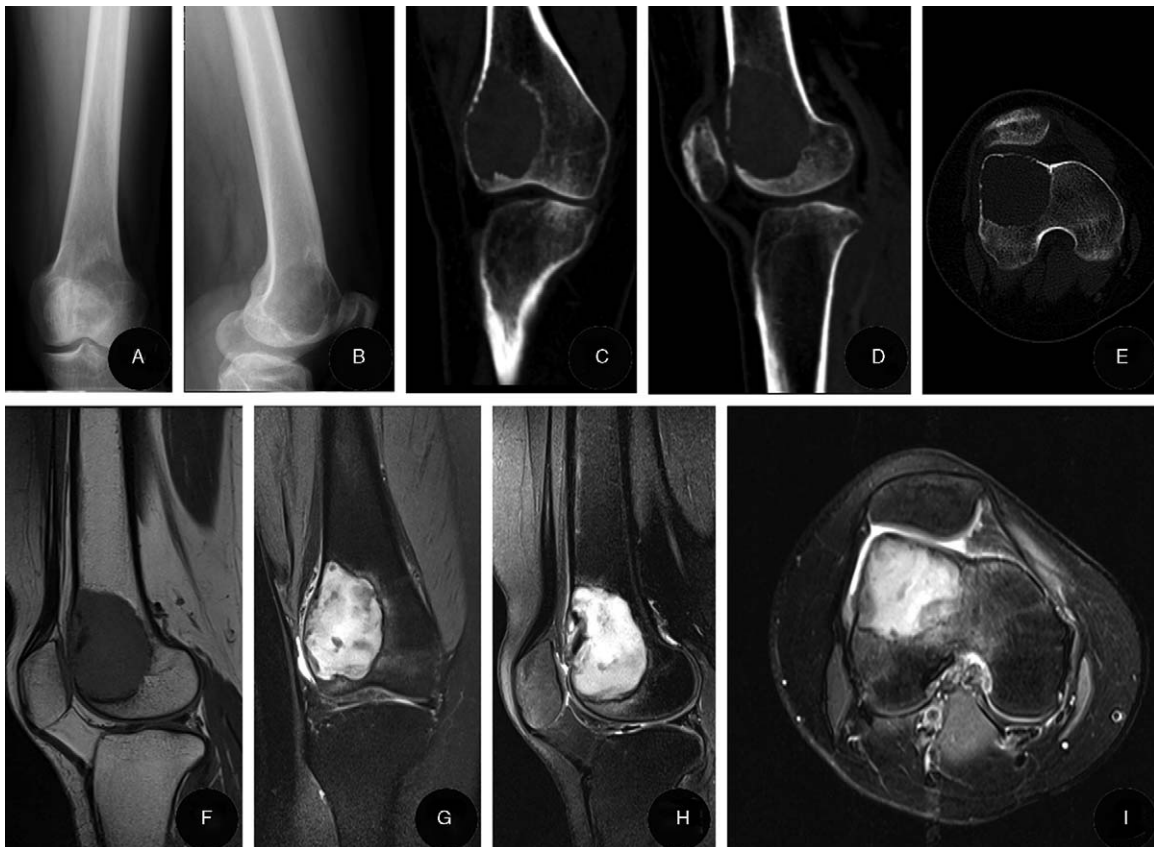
(A, B) Preoperative X-ray in a case of giant cell of bone of the distal femur showing cortical thinning and “donut sign.” (C–E) Preoperative computed tomography scan showing the appearance of a well-defined lytic cystic lesion. (F) Preoperative T1-weighted magnetic resonance imaging showing the lesion at the distal femur with relatively low-intensity change. (G–I) Preoperative T2-weighted image STIR showing a heterogeneous mixed high-intensity change with surrounding soft-tissue edema.
